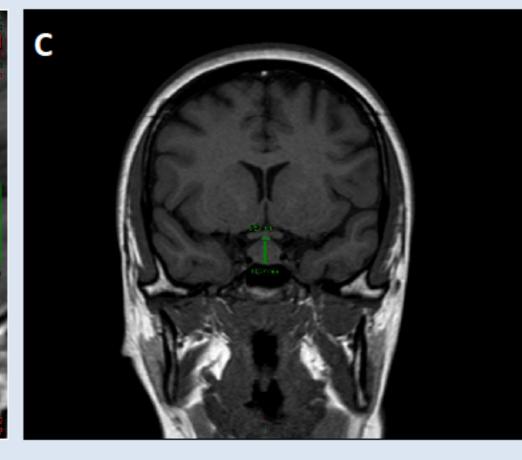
A. Unenhanced T1-weighted sagittal image: absence of the "bright spot" of the posterior pituitary. B. Post-gadolinium T1-weighted coronal image: homogeneous enhancement of the pituitary gland. C. T1-weighted coronal image: enlarged pituitary gland (12.8 mm) with thickening of pituitary stalk (3.63mm).
